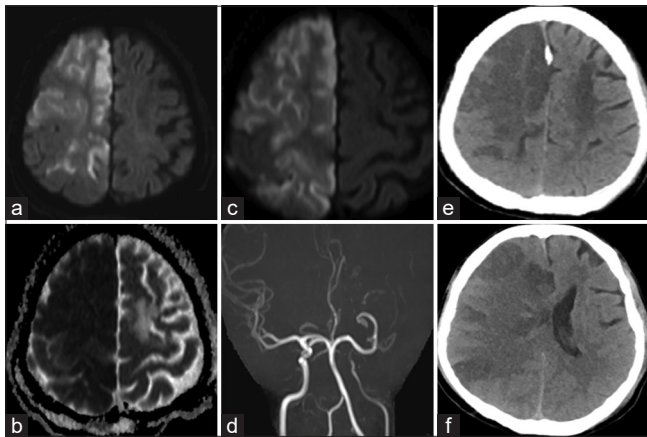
Radiological images of the brain – magnetic resonance-diffuse weighted images (a and c) showing hyperintensities in the right middle cerebral and right anterior cerebral artery regions with the corresponding hypointensity in apparent diffusion coefficient image (b). Magnetic resonance angiography of the carotid vessels showing left internal carotid artery occlusion (d). Computed tomography images of the brain (e and f) showing established infarct in the consistent region with mass effect and effacement of the ventricle
